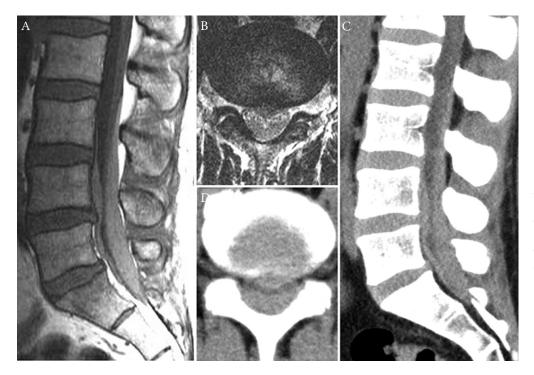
Preoperative magnetic resonance imaging (MRI) showing the hematoma extending from L2 to S1 appearing high intense on T1-weighted sagittal imaging (A) and isointense on T2-weighted axial imaging with a "three-branch star" appearance (B). Subsequent sagittal (C) and axial (D) computed tomography (CT) demonstrating an isodense chronic subdural hematoma extending from L2 to S1.
